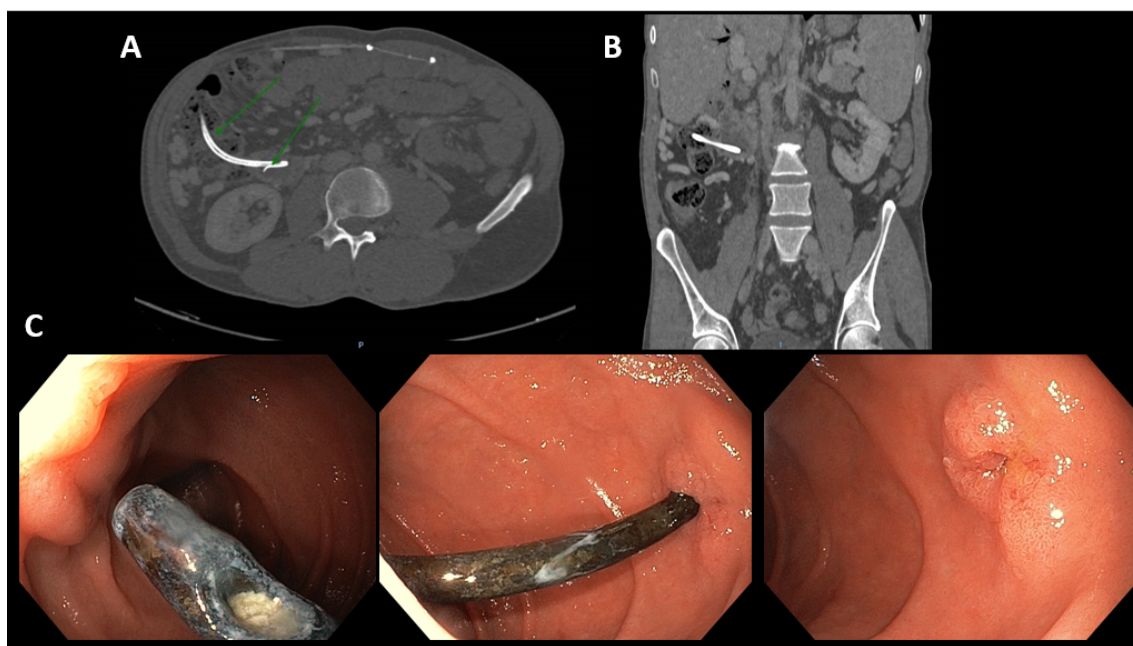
A and B. Computed tomography (CT) scan of the abdomen with intravenous contrast, axial (A) and coronal (B) sections, showing a migrated biliary stent with a fistulous tract between the second duodenal portion and the ascending colon. C. Phases of the endoscopic extraction of the stent, from left to right: proximal end of the migrated plastic biliary stent free in the duodenal lumen, distal end fistulizing through the posterior duodenal wall, and solution of continuity after stent extraction.
